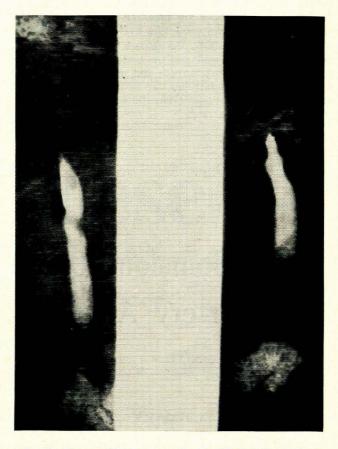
X-ray with the oesophagus filled with barium showing the indentation produced by the anomalous right subclavian artery (arrow).
